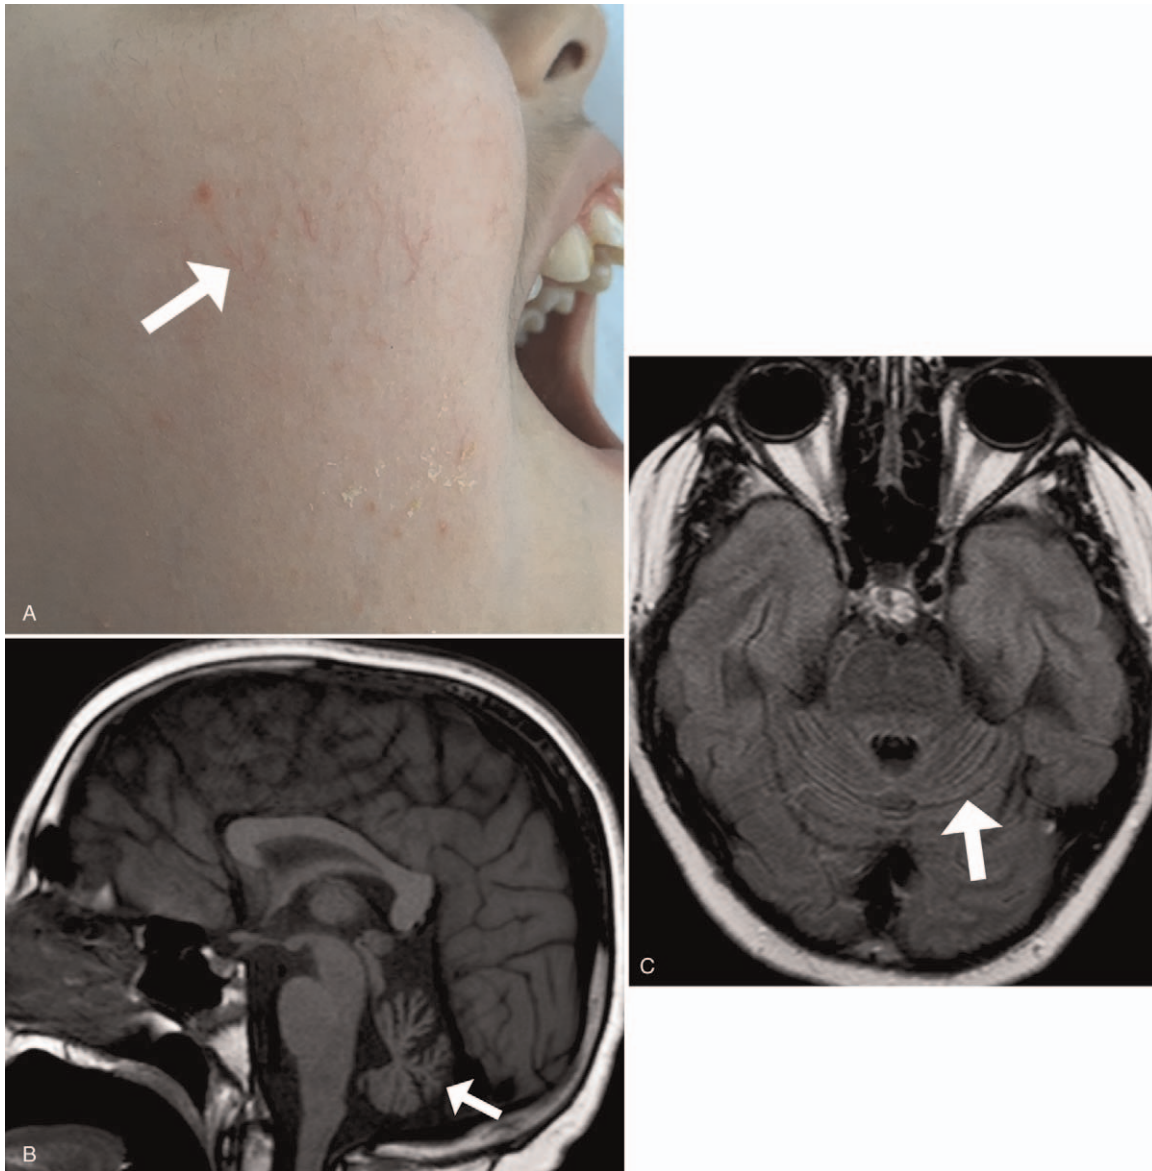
11-Year-old boy with ataxia-telangiectasia. Cutaneous telangiectasia on the right cheek (white arrow on A). Sagittal unenhanced T1-weighted image (B) and axial T2-FLAIR images (C) show diffuse cerebellar atrophy (white arrow on B) without signal abnormalities in the cerebellar cortex (white arrow on C).
